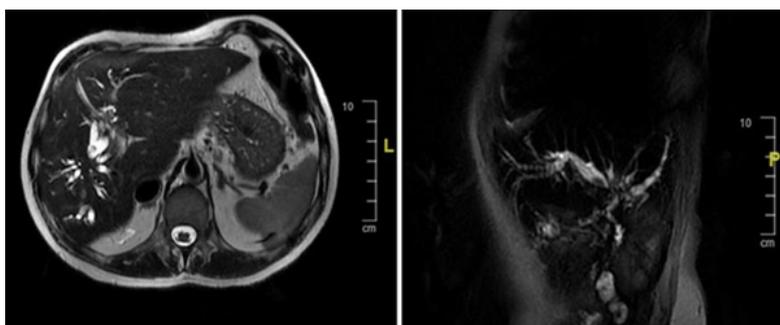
Hepatic MRI showing bile ducts dilatations and intraductal stones.
